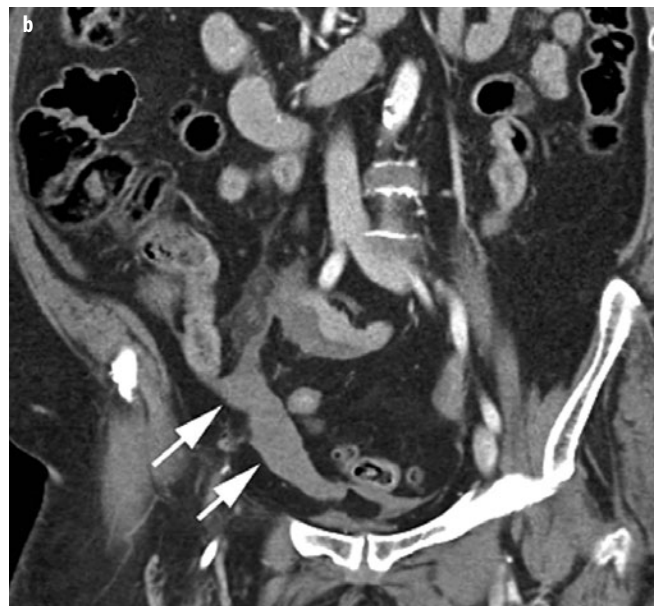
a, b. Hemoperitoneum due to mesenteric injury from motor vehicle collision. a Transaxial computed tomography (CT) image demonstrates high-attenuation fluid (*arrow*) adjacent to small-bowel loops. Increased attenuation within the mesenteric fat (*arrowhead*) is due to a mesenteric contusion. b Coronal image shows blood layering dependently within the peritoneal cavity (*arrows*, a and b)
